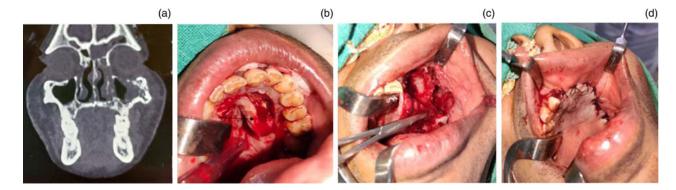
Case 6. (a) Coronal plane contrast-enhanced computed tomography of the nose, paranasal sinuses and orbit. (b) Intra-operative image. Black arrow indicates raised palatal flap. (c) Intra-operative image. (d) Intra-operative image after closure.
